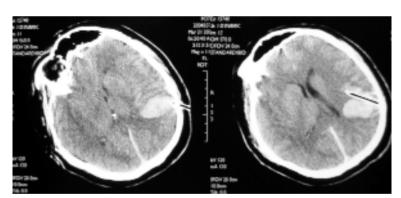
Pre-operative CT demonstrating the arrow and the hematoma.
